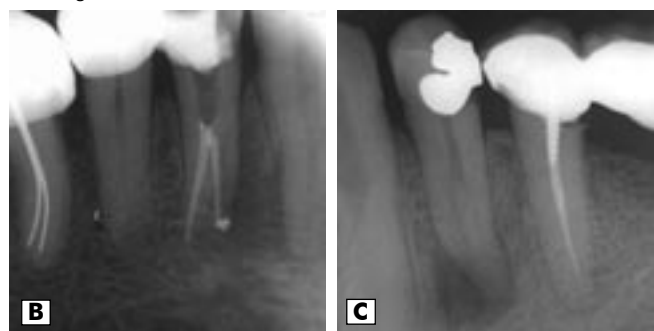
Variations in mandibular premolar anatomy. (A) single canal with ramifications in the apical one third (B) Single canal which bifurcate into two. (C)A good off angled preoperative radiograph helps the clinician to anticipate bifurcated premolars.
